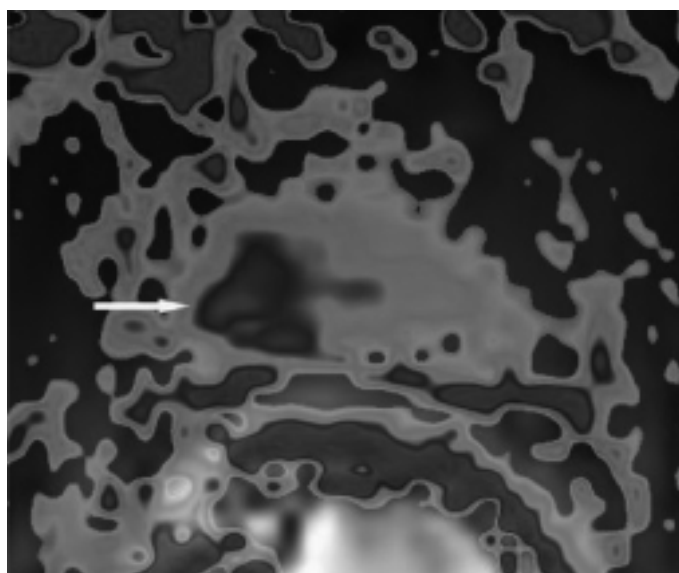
DCE MR images with TSR regions visible
